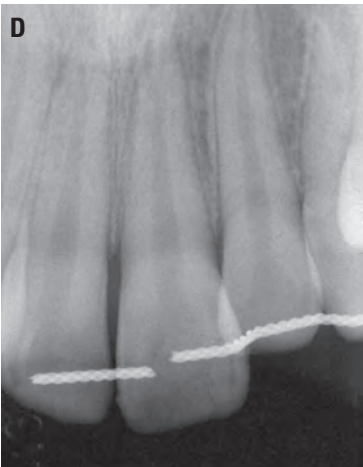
Continued. B, The tooth was brought to the dentist in milk. At the dental office, the tooth was examined and placed in saline during the examination of the avulsion site. C, The tooth has been replanted and splinted. Note the suturing of gingival tissues to improve adaptation. D, Radiograph of replanted tooth. Before removing the splint, root canal treatment is started, optimally 10 to 14 days post-replantation. Continued on next page.
